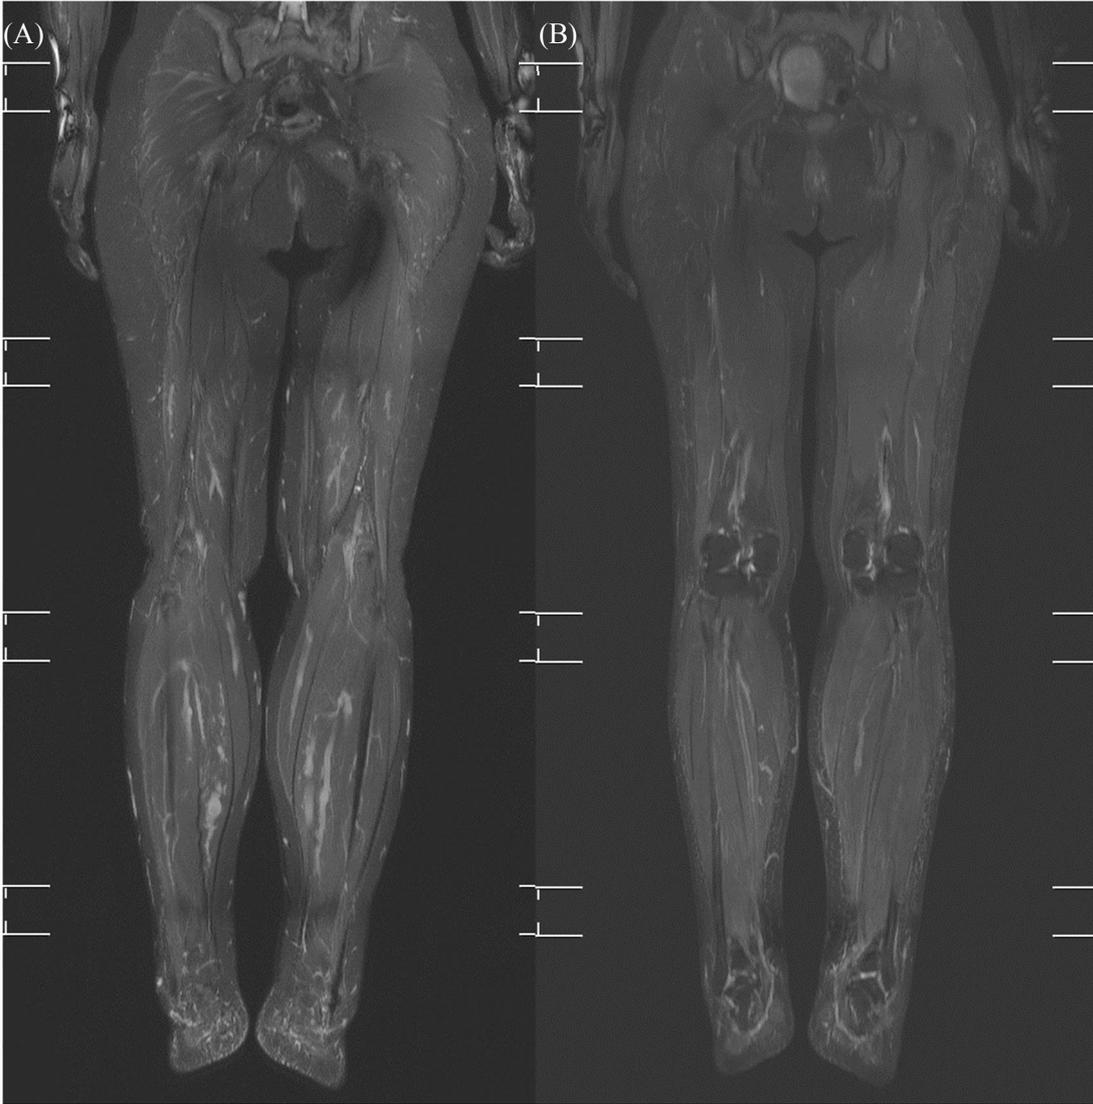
The change of MRI findings in patient 3 after administration of alpelisib. (A) The MRI image of both lower legs before treatment (B) The MRI image of both lower legs after treatment. The extent of fine stranding of subcutaneous layer of bilateral distal lower legs decreased. Minimal improvement of tortuous and dilated deep and superficial venous structure in lower extremities was observed.
